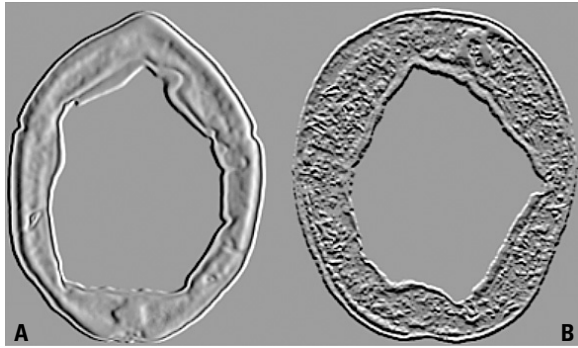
Comparison of the image texture of the transverse section of the calvarial bones in the young (A) and old individual (B). Reconstruction based on axial CT-scans with implementation of the embossing procedure.
